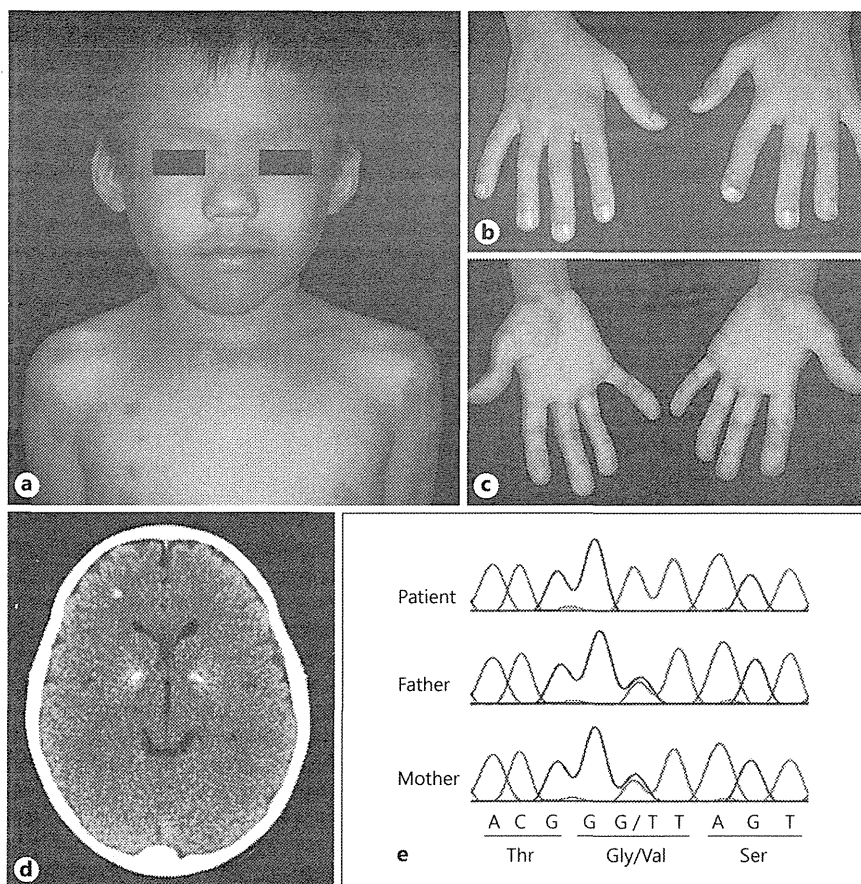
Clinical photographs (a–c), cranial CT (d) and genomic analysis of the patient at 5 years of age (e). A thin angular face (a), long clubbed fingers with swollen interphalangeal joints (b, c) and calcification of the basal ganglia on cranial CT scans (d) were observed. e Electrophoretograms of the genomic sequence of the patient and his parents. A c.602G>T mutation causing an amino acid substitution of Gly201Val was found homozygously in this patient and heterozygously in both parents.
